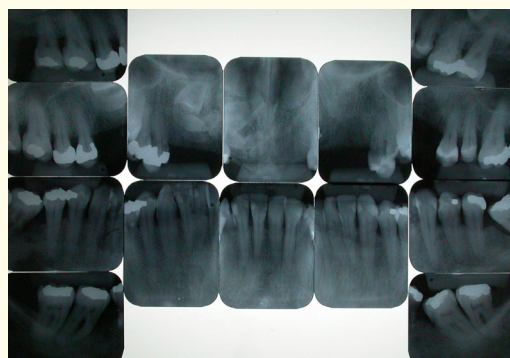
Radiopaque images observed in the edentulous region of teeth 11, 12 and 13 (periapical radiograph).
